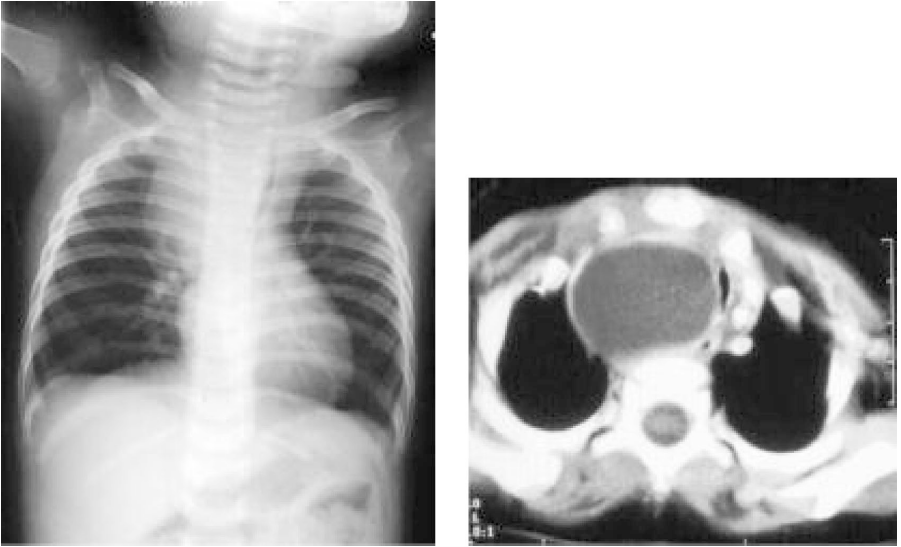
Plain X-ray showing upper mediastinal widening and vertebral defects. CT scan thorax shows an enhancing rim of an oesophageal duplication cyst. This was excised by right thoracotomy.
